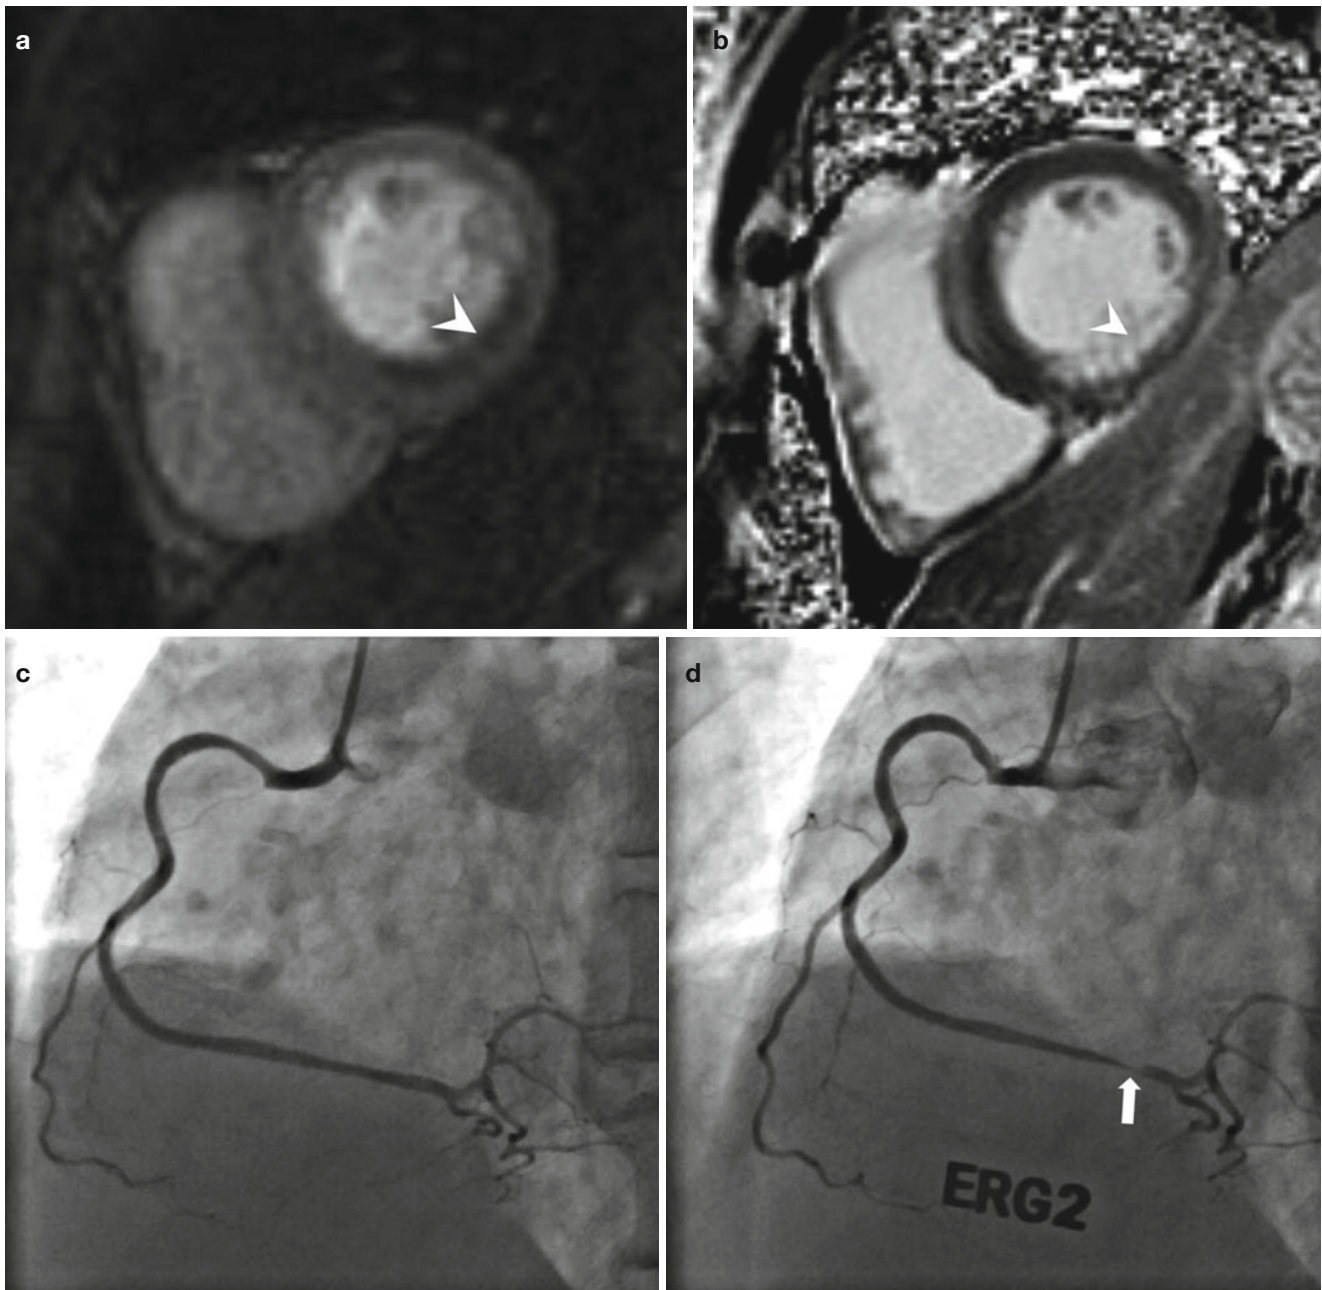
A 61-year-old man with acute chest pain (Courtesy of Hyun Ju Seon, Chonnam National University Hospital). (a) Resting perfusion MR image shows subendocardial perfusion defect (*arrowhead*) at mid inferoseptal and inferior wall, indicating the territory of the right coronary artery. (b) Ten-minute delayed MR image using phase-sensitive inversion recovery sequence after administration of gadolinium contrast shows subendocardial delayed enhancement at the same area
